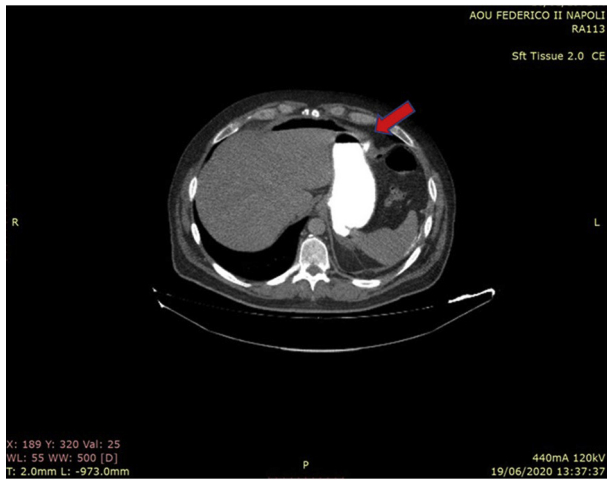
Abdominal CT showing leak of oral contrast into the abdominal cavity. CT = computed tomography.
